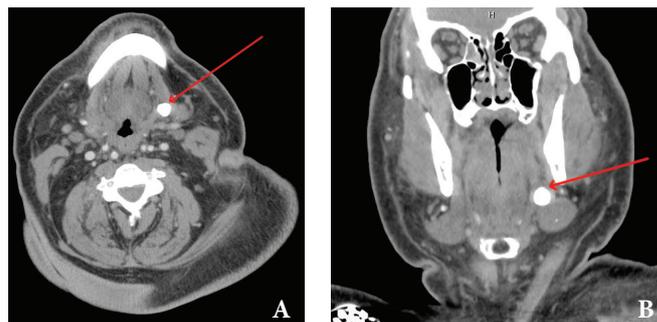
Non-contrast CT images (A, B) with arrows pointing to sialolith in the left submandibular gland duct (Wharton's duct).
